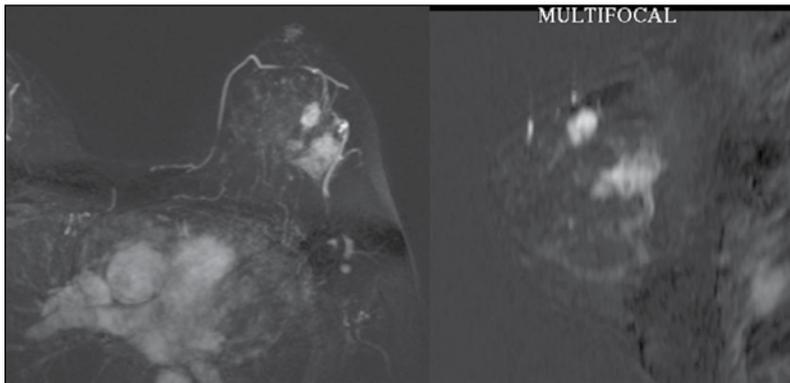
A second focus was found in a patient's magnetic resonance imaging. A wider lumpectomy was considered necessary
